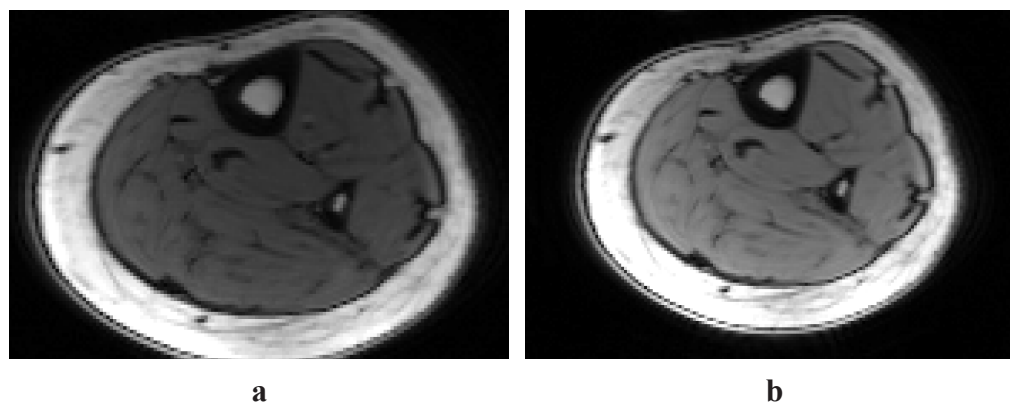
STE-MR images of axial human mid-shaft tibia of a 24 years old female a) TR=20 ms, b) TR=60 ms.
